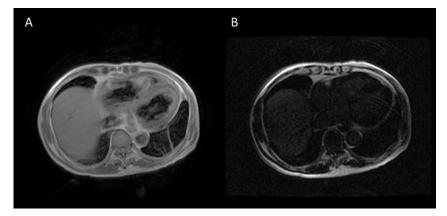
Cardiac magnetic resonance imaging (MRI). T1 weighted image (panel A) revealed no increased signal intensity of RV myocardium as subcutaneous fat. Delayed myocardial enhancement image (panel B) revealed no delayed enhancement of RV myocardium.
